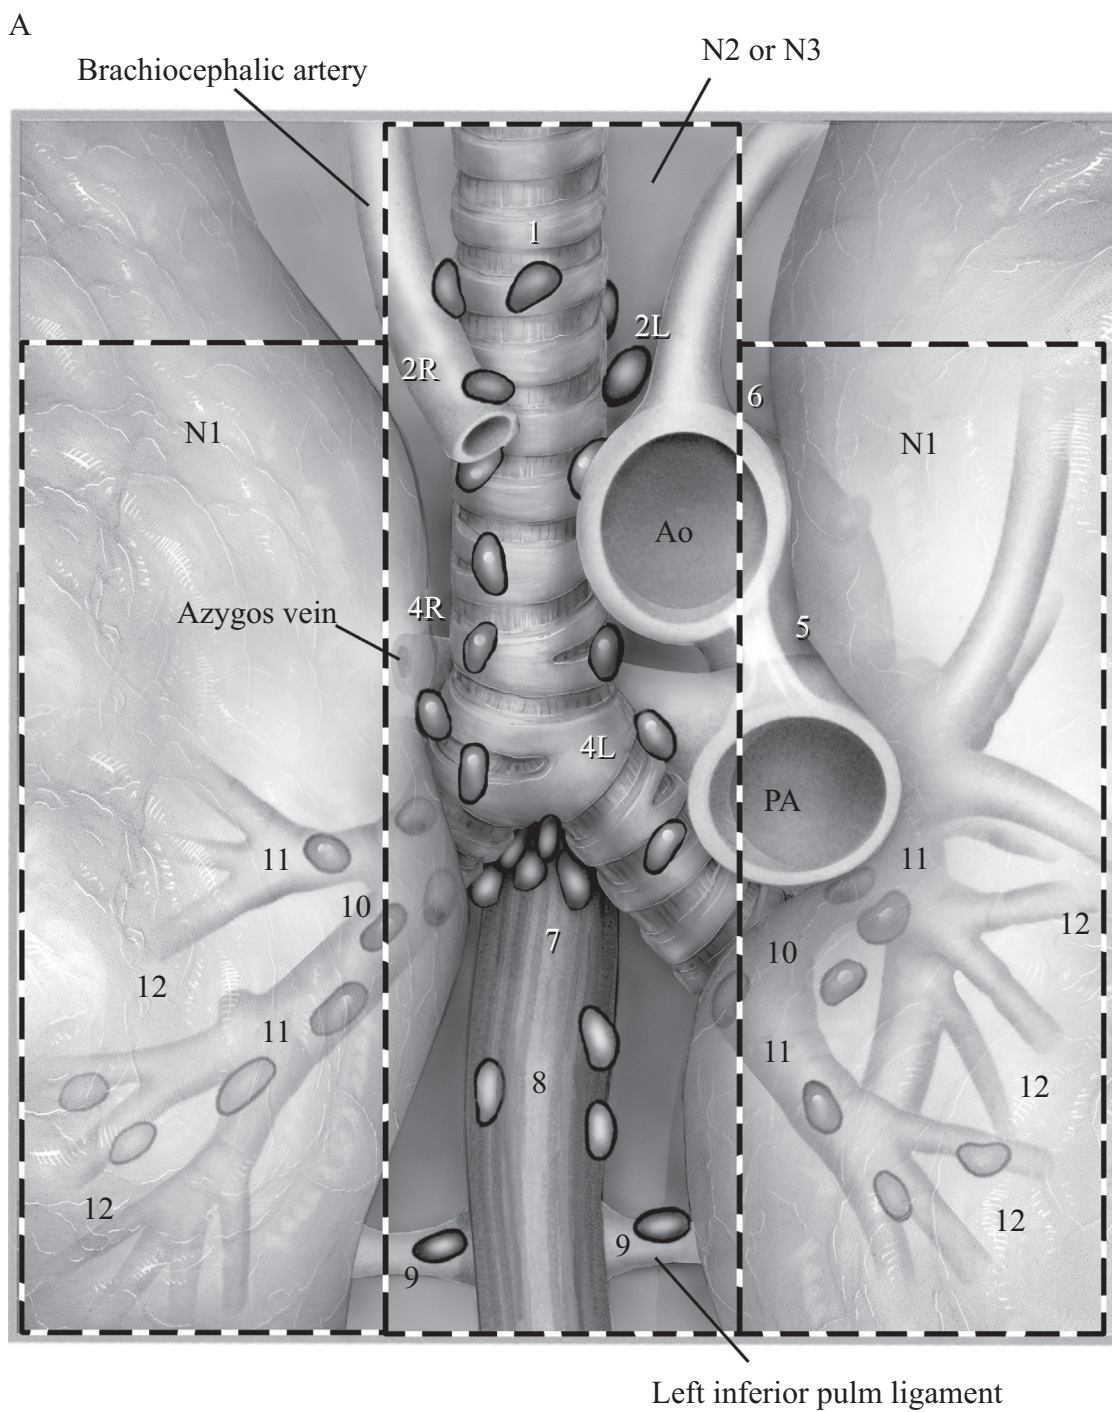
(A) Once a suspicious lung nodule is identified, a biopsy is typically obtained by either computed tomography-guided or navigational bronchoscopy and the patient is staged to determine N1-, N2-, or N3-category disease.
